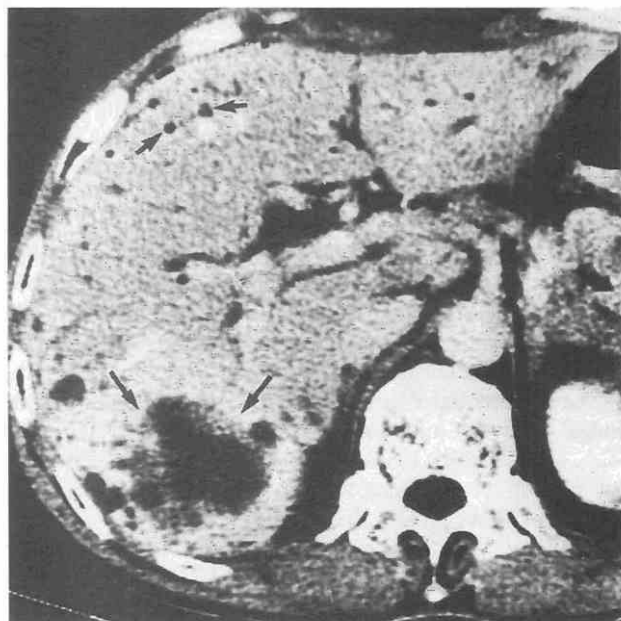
Clonorchis* infection with dilated intrahepatic bile ducts (short arrows) and an intrahepatic cholangiocarcinoma (long arrows). (From Choi BI, Kim HJ, Han MC: CT findings of clonorchiasis. *AJR Am J Roentgenol* 152:281, 1989.)
